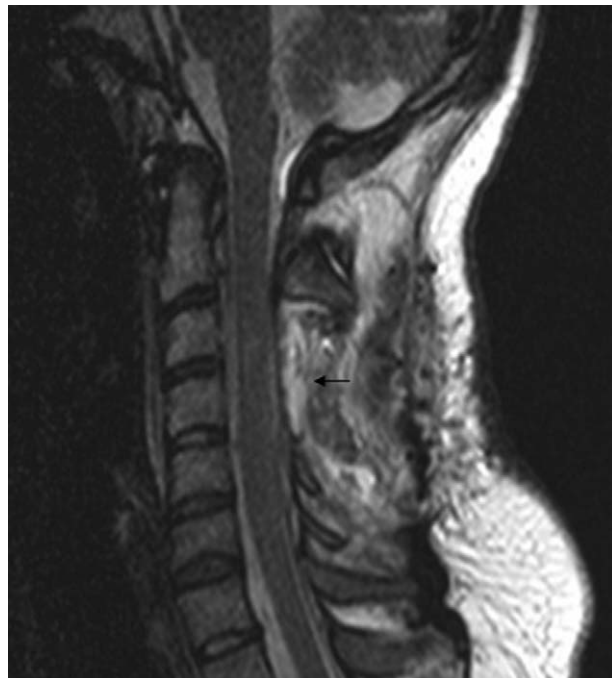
Postoperative sagittal T2-weighted cervical spine magnetic resonance imaging (MRI).
